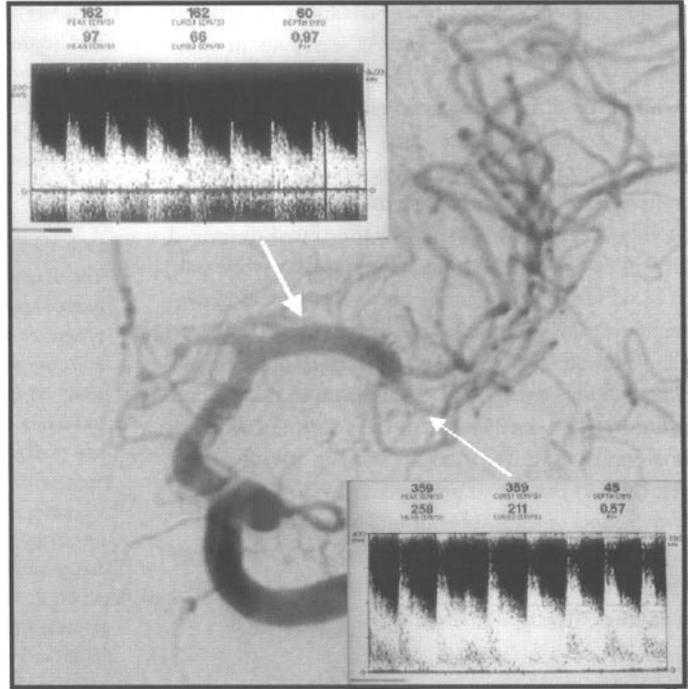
M2 middle cerebral artery (MCA) vasospasm. A left internal carotid angiogram showed improvement in vessel diameter after balloon angioplasty for a severe proximal M1 MCA vasospasm (see Figures 11.1 & 11.2). Transcranial Doppler showed mean flow velocities of 97 cm/s in the M1 MCA after angioplasty (upper waveform), and M2 MCA mean flow velocities of 258 cm/s (lower waveform), indicating development of spasm in more distal branches.
